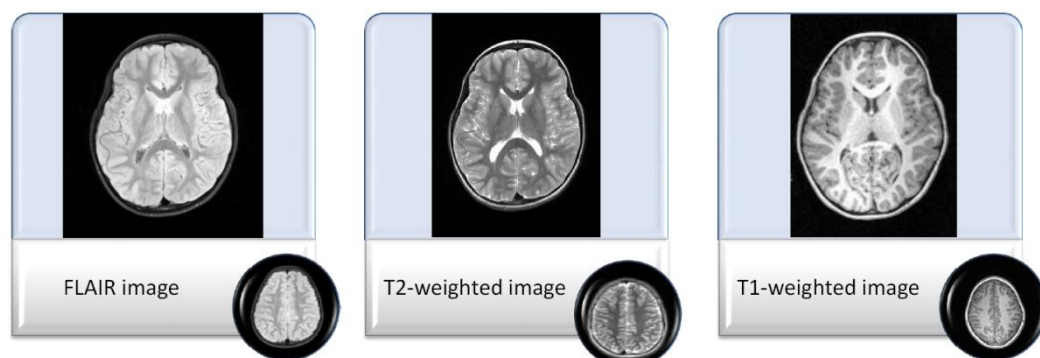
Transversal FLAIR, T2 and T1 images acquired in a 3 T scanner. Images of a child with antecedents of prematurity (GA: 29 w, BW: 1220 g) at 8 years of age.
